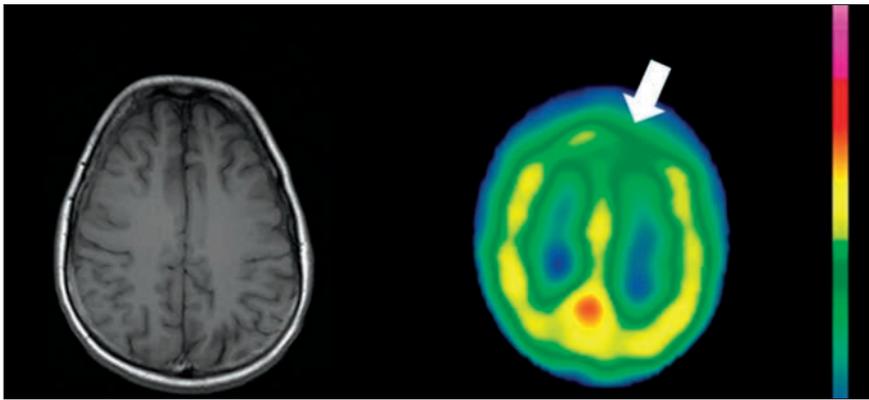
Scans in a patient with a head injury sustained in a motor vehicle accident 4 years previously, who subsequently developed altered personality, cognitive fallout, and depression. The MRI scan (left) is normal, while SPECT shows anterior frontal hypoperfusion consistent with mTBI.
